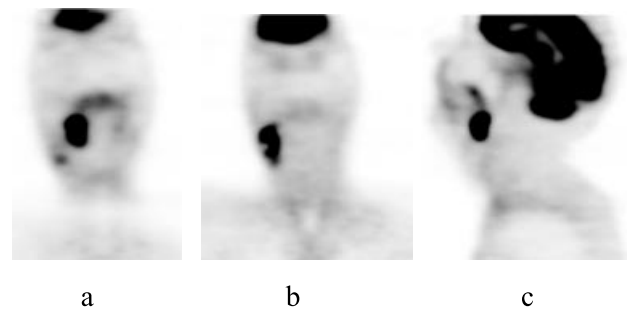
Head and neck cancer patient of 42 year old male with a squamous cell carcinoma of the right tonsil. a) Intense uptake is present in the primary tumor of the right tonsil with metastatic node. b) A nodal disease is obvious in the right neck with necrotic part. c) Sagittal image of the primary tumor. Maximum SUVs of primary tumor : 10.7, right neck node : 8.5
